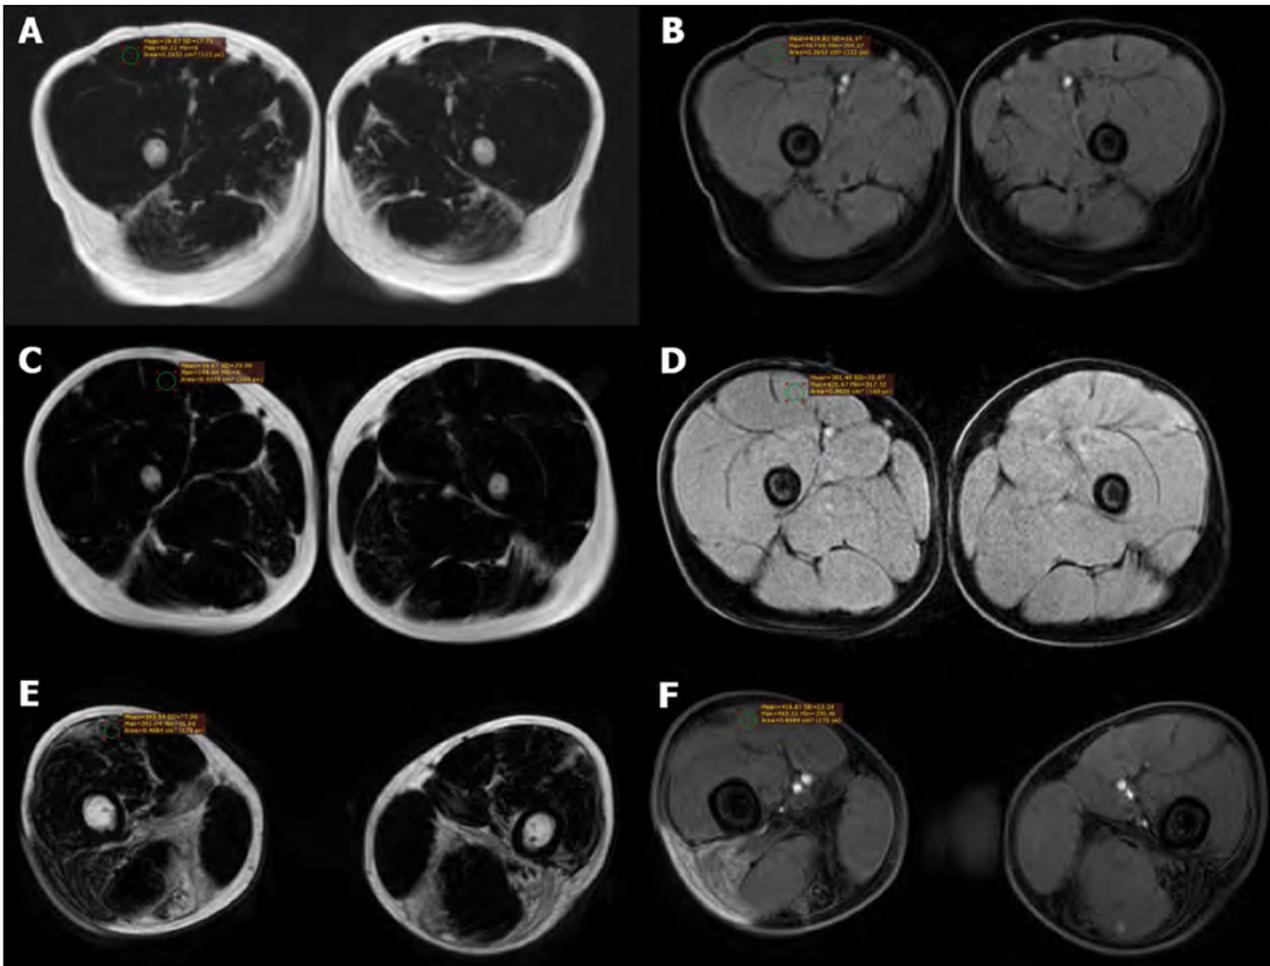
Axial MRI image (mDixon sequence) in three different patients with DMD showing fat (A, C & E) and water (B, D & F) signal. The mean fat signals were 29, 35 and 143 respectively while those of water were 430, 351 and 416 respectively.
